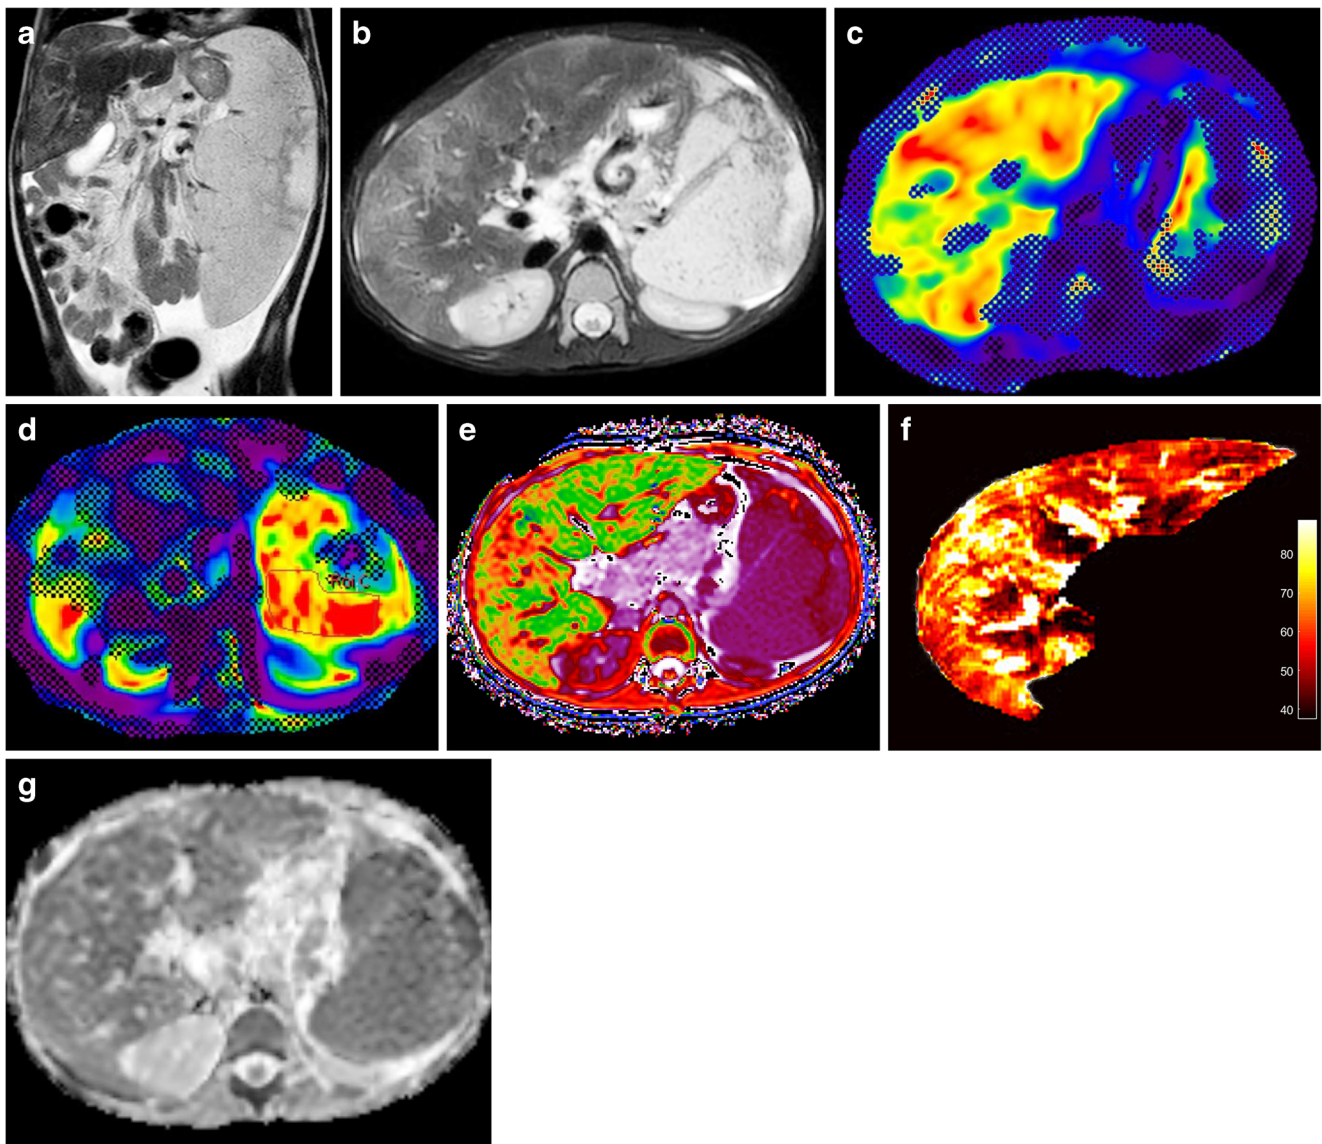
Autoimmune liver disease in a 7-year-old boy. a, b Coronal single-shot fast spin-echo (a) and axial T2-weighted fast spin-echo fat-saturated (b) MR images show areas of geographic liver signal hyperintensity, marked splenomegaly (with an area of splenic infarction) and ascites. c, d MR elastography images of the liver (c) and spleen (d) show abnormally increased stiffness (4.8 kPa and 7.4 kPa, respectively). Note that the splenic region-of-interest was drawn to avoid the area of splenic
